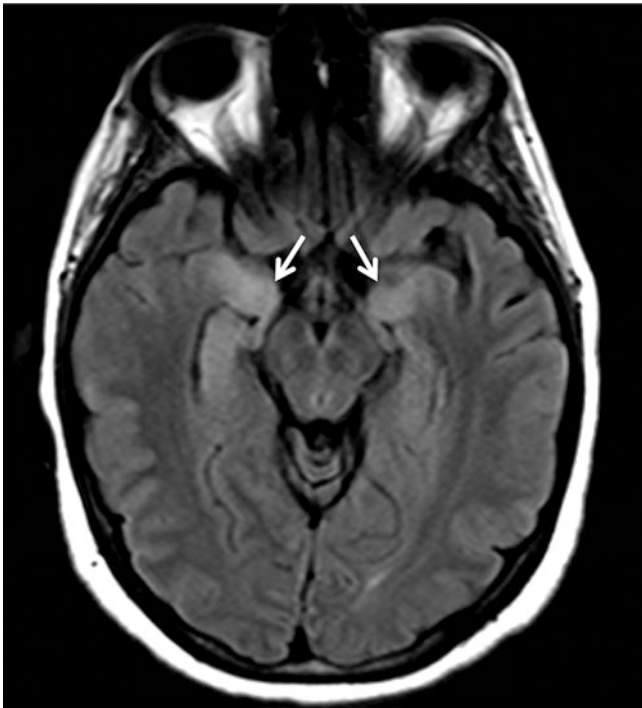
Single FLAIR axial brain MR image in an emergency department patient with small cell lung cancer and altered mental status depicts bilateral medial temporal hyperintensity (*arrows*). Diagnosis of paraneoplastic limbic encephalitis was based on clinical and imaging characteristics
